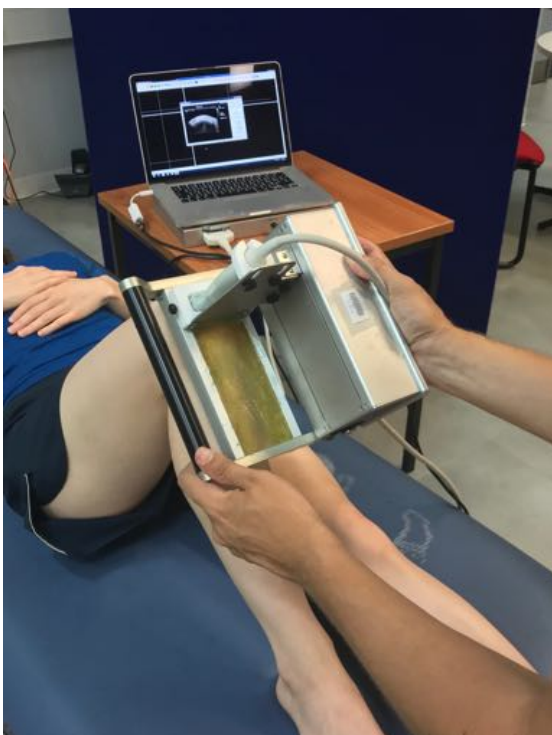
Ultrasound tissue characterization tracker and stand-off pad (above)
